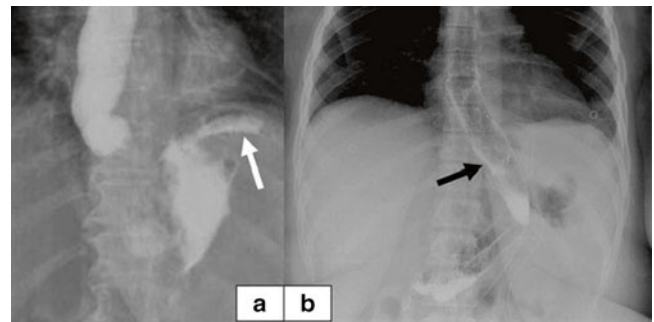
(a) Gastrografin esophagography with gastric leak on the upper third of the staple line (white arrow). (b) Abdominal X-ray showing two covered SEMS inserted in order to bypass the gastric leak (black arrow). Reproduced with permission from *OBES SURG* 2012;22:712-720. Is There a Place for Pigtail Drains in the Management of Gastric Leaks After Laparoscopic Sleeve Gastrectomy?.
